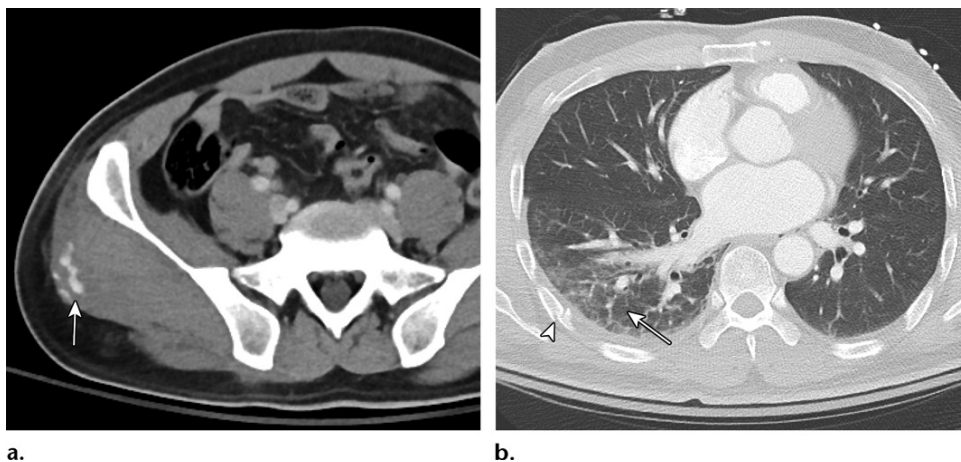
MLL of the right gluteus medius in a 44-year-old man after a fall down stairs. (a) Axial contrast material-enhanced CT image shows low-attenuation expansion of the right gluteus medius muscle, with areas of contrast material extravasation (arrow) indicating active bleeding. This patient ultimately underwent empirical embolization of the right superior gluteal artery, although no active extravasation or pseudoaneurysm was seen at the time of angiography. (b) Axial CT image shows that the patient also had a minimally displaced right-sided rib fracture (arrowhead) and a right lower lobe lung contusion (arrow).
